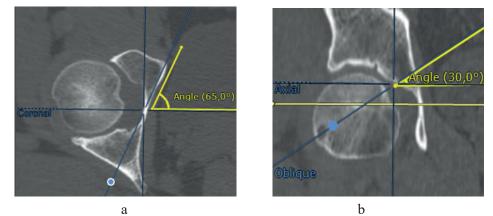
Stages of CT-image reconstruction while obtaining topogram for assessment of the acetabular medial wall width: a – horizontal CT-image at the level of the centre of acetabulum; δ – reformed image with 65°-inclination to the sagittal axis.
